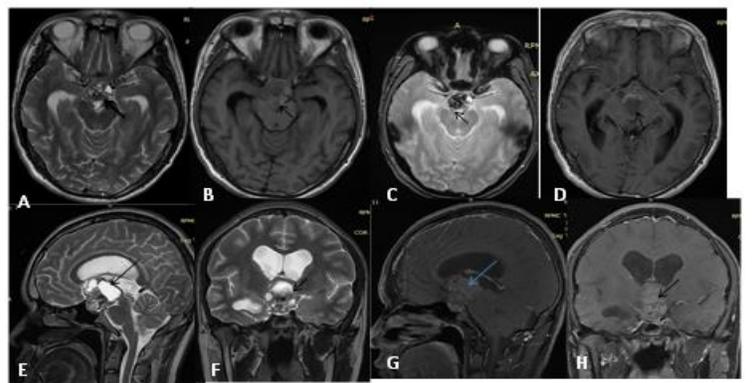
(A-H): A 12 year old female presenting with headache and vomiting for 5 months MR images shows multiloculated solid cystic mass in suprasellar region which is obliterating the 3rd ventricle and causing lateral ventricle prominence as seen in axial T2W, T1W, GRE, POST CONTRAST (A-D); Saggital T2W, POST CONTRAST (E,G); Coronal T2W and POST CONTRAST (F,H): shown by arrow. Axial GRE Image clearly shows area of blooming. On post-contrast images it shows enhancement of the solid component.
